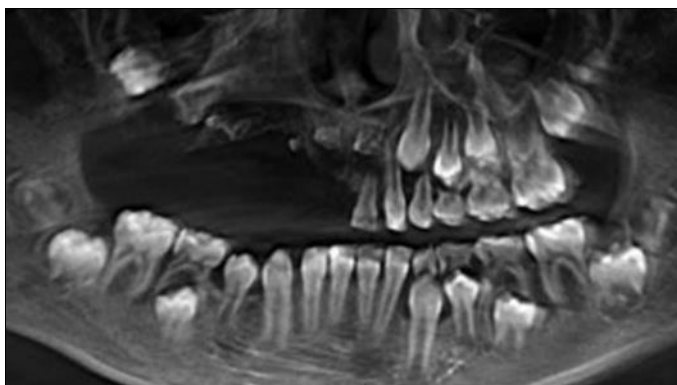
Previous digital panoramic radiograph was taken in childhood stage. The affected teeth revealed a faint outline appearance (red arrow), devoid of root development and no distinction between enamel and dentin structures (yellow arrow)
